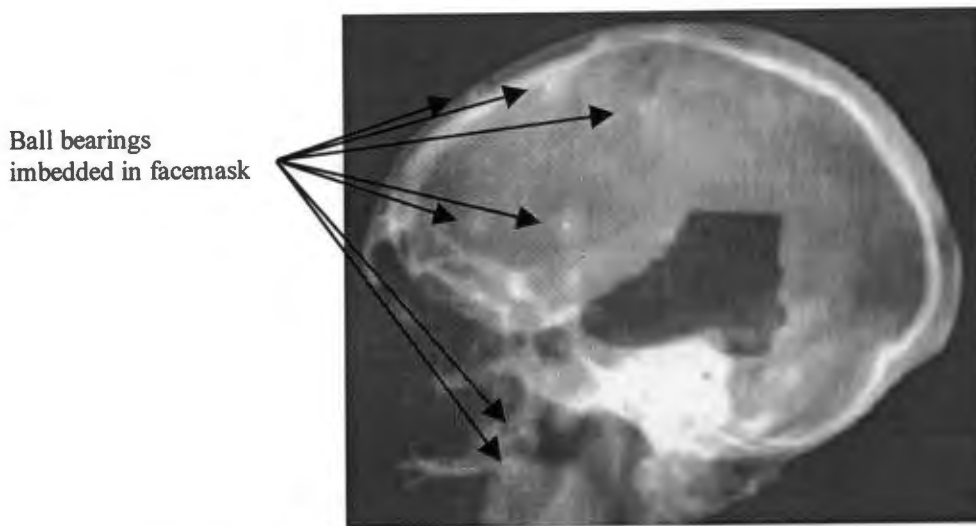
Typical verification double-exposure X-radiograph with the collimator outline superimposed on the anatomical image. The 1 mm diameter ball bearings imbedded in the patient's mask are clearly visible.
